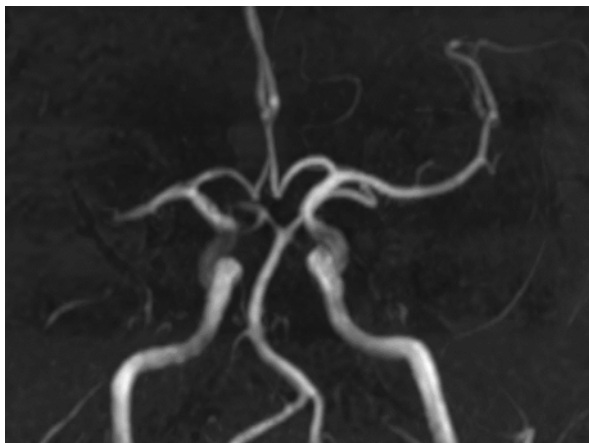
CT angiography (maximum intensity projection (MIP) reconstruction) demonstrates the presence of an embolus in the right internal cerebral artery bifurcation and lack of flow in both proximal AI segments of ACA and M1 of the MCA. Distal AI segment of the right ACA is filled by the anterior communicating artery and contralateral ACA. Collateral vessels are not seen in the right hemisphere
